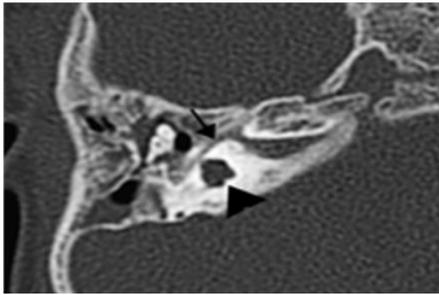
Cochlear aplasia. Shaped axial CT scan of right temporal showing absence of cochlea, arrowhead showing dysplastic right vestibule. There was also a mild right facial nerve abnormality indicated by the arrow activation mechanism
